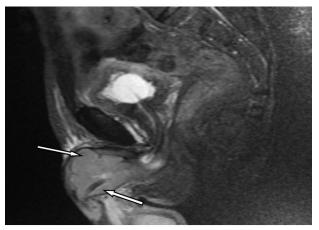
Sagittal T2 weighted MRI showing iso-hyperintense mass at the base of penis with loss of fat plane
